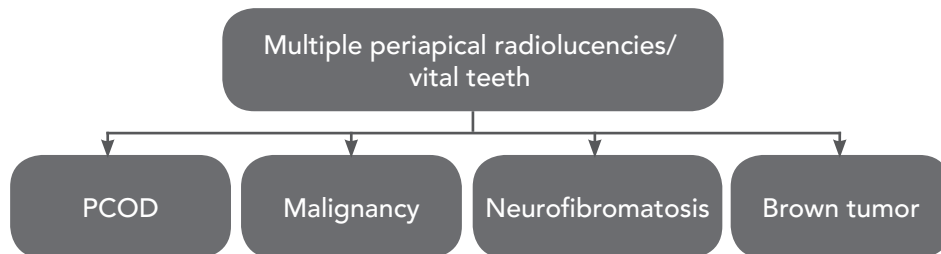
Differential diagnoses for multiple periapical radiolucencies associated with vital teeth.
